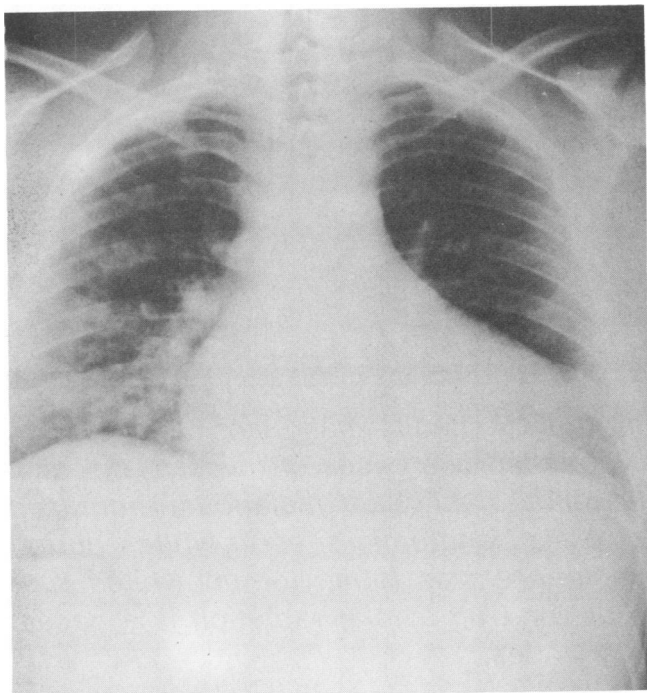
Chest roentgenogram of patient 5 showing a bronchopneumonic infiltrate in the right lower lobe.
